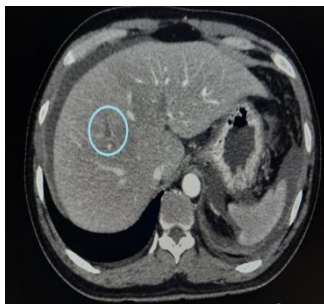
Contrast enhanced CT showing thrombosis in portal vein division
